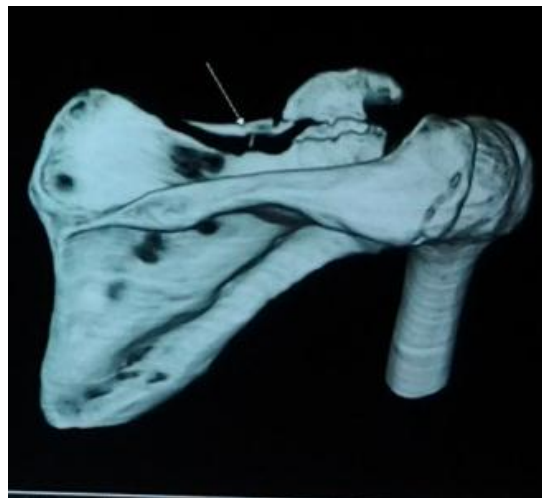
Reconstructed shoulder CT showing the fracture of the upper border of scapula- marked with an arrow
